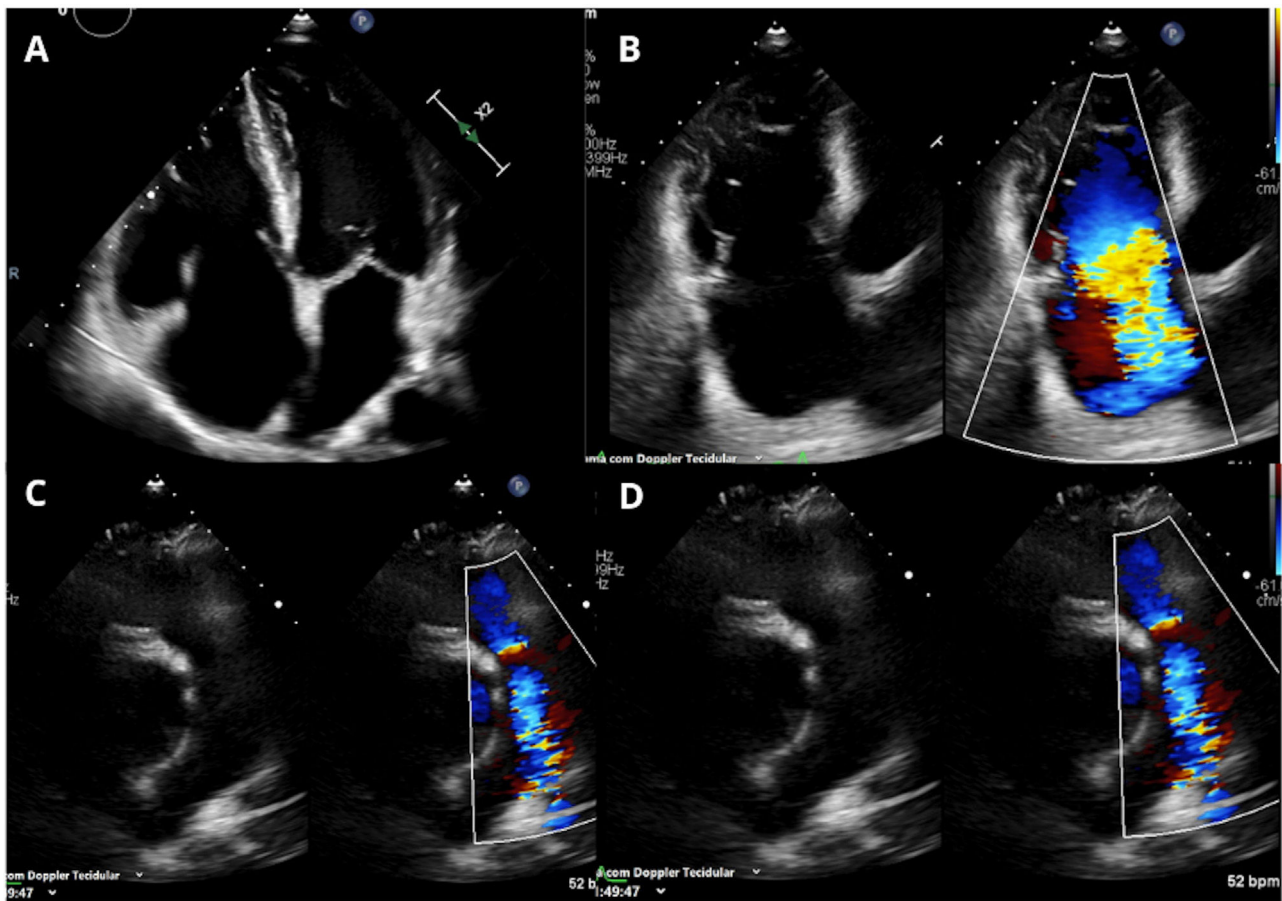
Transthoracic echocardiogram showing: thickening and immobility of the tricuspid leaflets (A) and torrential regurgitation (B and C). Thickening and restriction of the pulmonary valve (D) with moderate regurgitation and mild stenosis (D).
